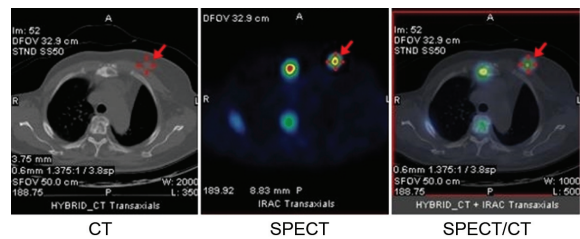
CT, SPECT, and SPECT/CT fusion images showed increased Tc-99m-HYNIC-TOC at left breast mass at upper inner quadrant (arrow). Other increased uptake foci were seen at sternum, rib and vertebral body, suggestive of osseous metastasis.
